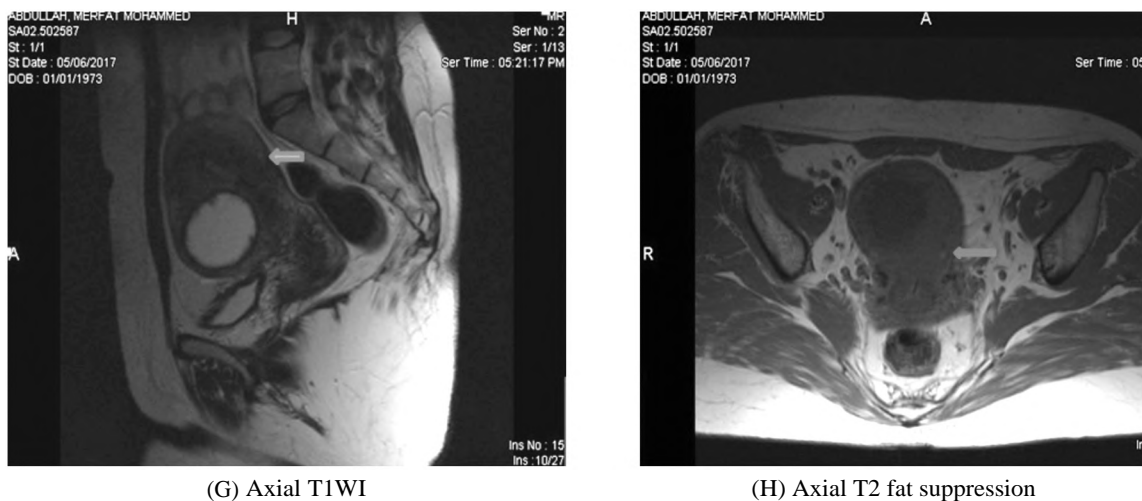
Female patient 36 years old, presented by abnormal uterine bleeding following short period of missed menses, history of previous 3 CS, Pelvis ultrasound (TVS) was done showed bulky uterus has anterior wall uterine cyst (A,B) was first suspected to be abnormal gestational sac cause of its position near to endometrium but B-HCG was negative at two subsequent lab results, MRI pelvis was done and revealed uterine adenomyosis (C-F) sagittal T2 WI showed bulky uterus with increased JZ thickness in comparison to total myometrial thickness at same level (measures), hyper intense anterior wall myometrial cyst seen within ill defined thickened JZ with hypo intense wall (arrow) noted within mid anterior portion of JZ (C), cyst noted hypo to iso intense in T1WIs (E,H) cyst take no enhancement at post contrast sequences but its wall take enhancement as well adjacent JZ and myometrium (F). Notice hyper intense focus at posterior wall noted at sagittal T2WI and axial non contrast T1WI (arrows at Fig. 2G,H).
